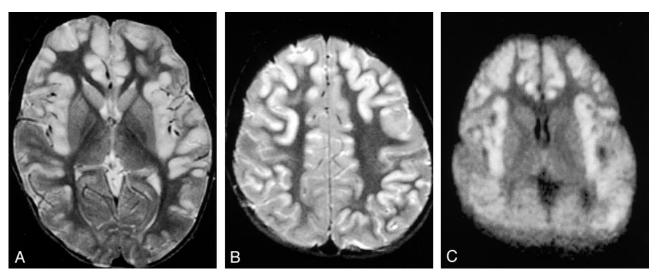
MR images in patient 2 obtained 2 days after the onset of symptoms.
